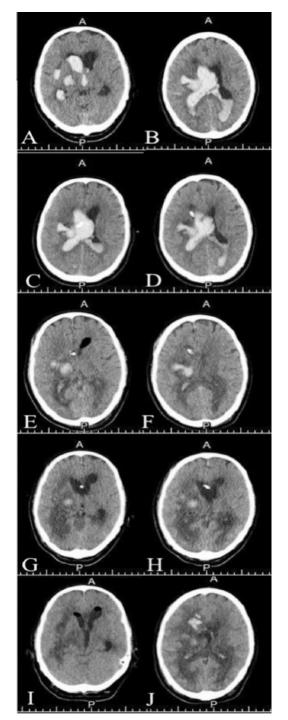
A and B show the ictal CT scan of Patient A. C shows first EVD misplaced to the right. D shows the stability scan after revision EVD. E and F show the scan after giving rtPA. G and H are scans during EVD challenge at end of treatment. I and J show post-removal of EVD with pneumocephalus, catheter-tract hematoma and perihemorrhagic edema.
